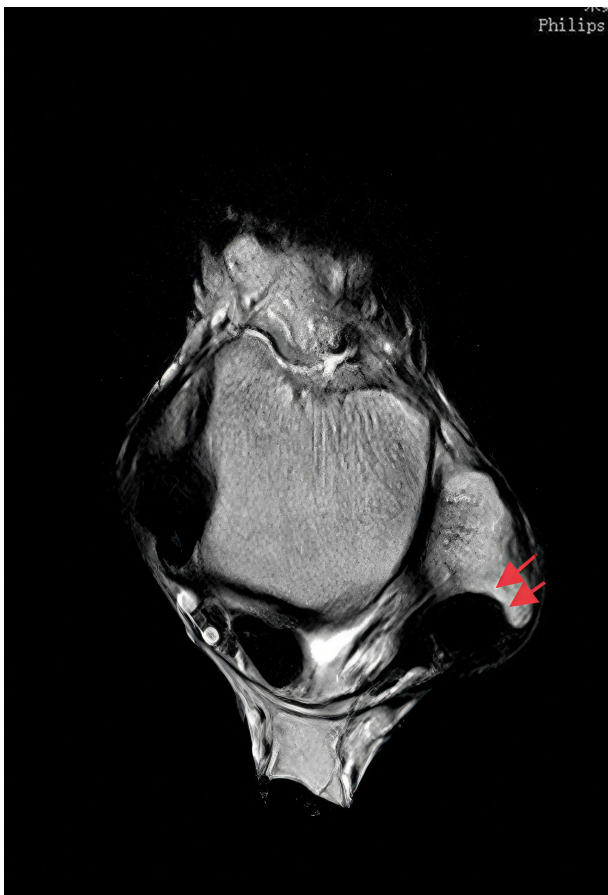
A magnetic resonance imaging examination showing that the fibular tendon had filled up the deepened fibular groove in the ankle joint. As indicated by the arrow in the picture: the deepened fibular groove.
